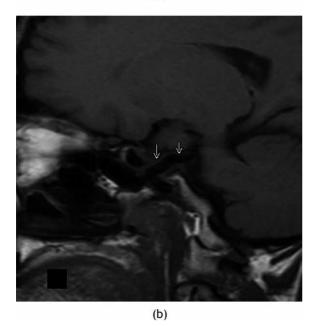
(a) Axial T2- and (b) sagittal T1-weighted images of the brain showing an abnormal vessel (persistent trigeminal artery) joining the cavernous portion of the left internal carotid artery and the distal basilar artery.
